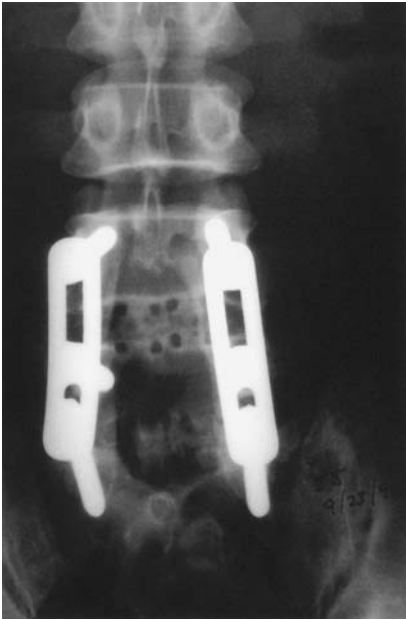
Four-year postoperative AP x-ray shows solid bony fusion in all areas, including the bone inside the cage on the right at L4-5. (From Ref. 33.)
